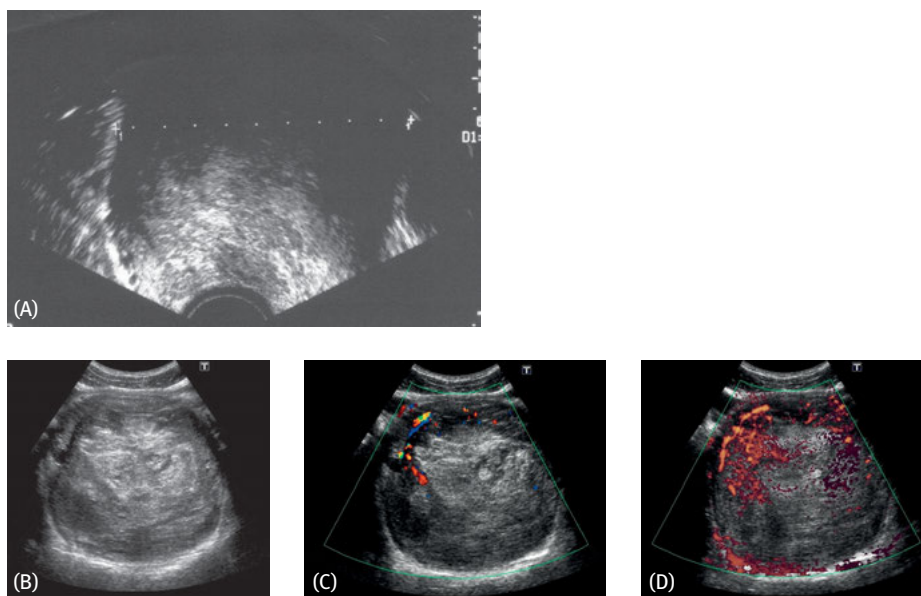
(A) vaginal sonography of the rhabdomyosarcomas depicted in Fig. 3.1.1. The tumor has heterogeneous echogenicity with sometimes diffuse, sometimes irregular bizarre margins between the regions of different echogenicity; (B) embryonal uterine rhabdomyosarcoma with a diameter of 13×10 cm and positive lymph node involvement in a 19-year-old woman. The heterogeneous and inhomogeneous echogenicity with diffuse boundaries/margins between the areas of different echogenicity is striking; (C), (D) color Doppler sonography shows that the anechoic voids in (C) in part correspond to vessels and serve to evidence the tumor's massive degree of central vascularity.
